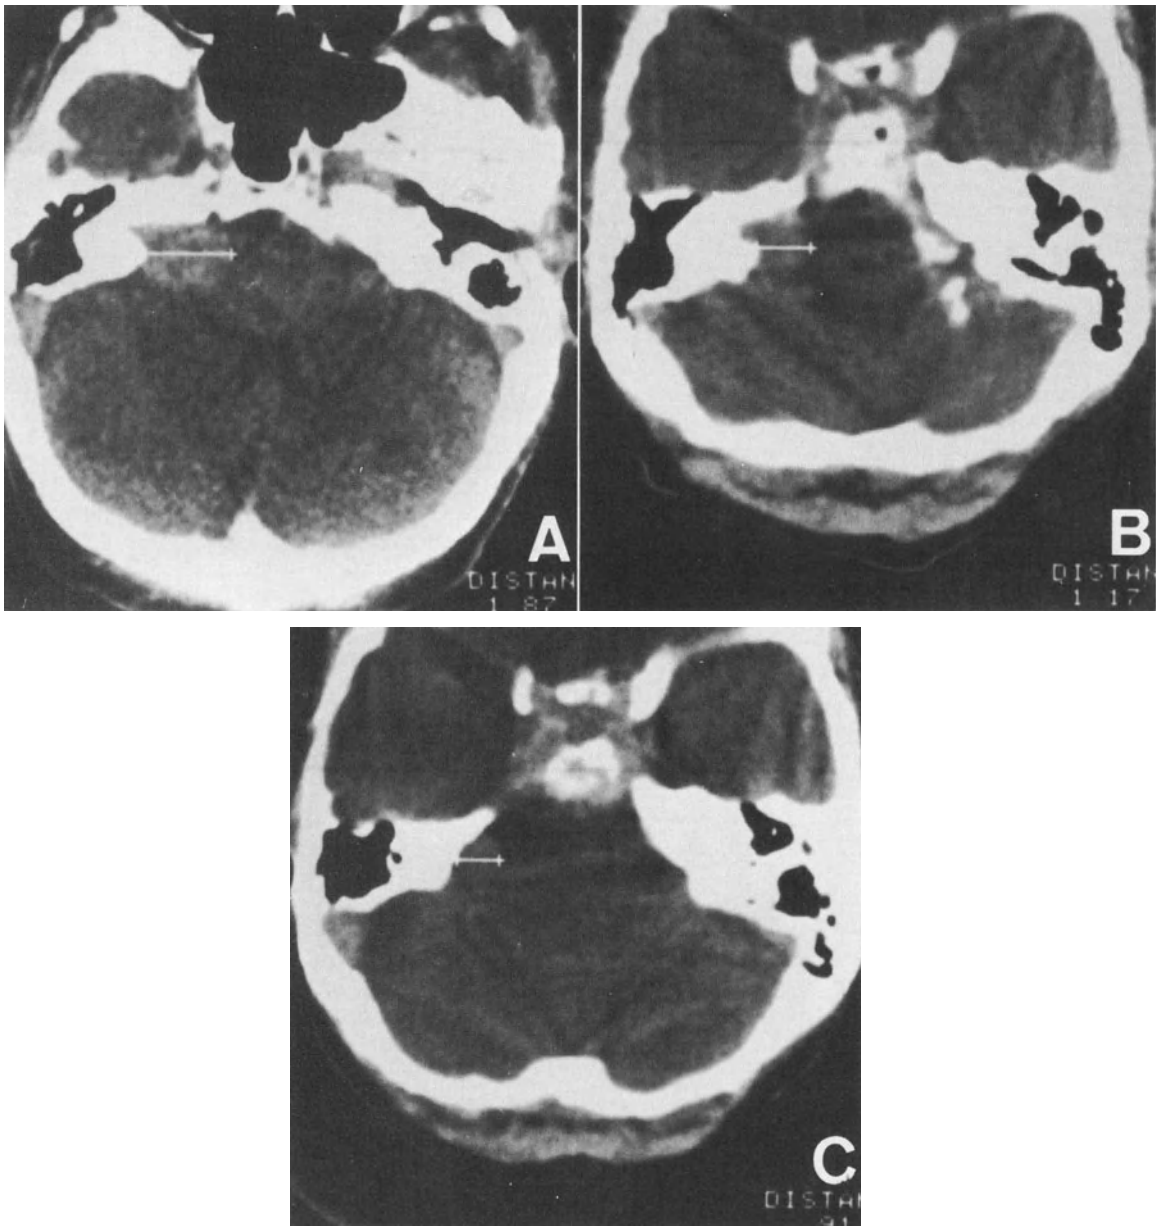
CT of acoustic neurinoma before (A), 14 (B), and 25 (C) months after stereotactic radiosurgery. A gradual decrease of the tumor size is seen. No obvious change in the CT attenuation pattern followed intravenous contrast administration.
